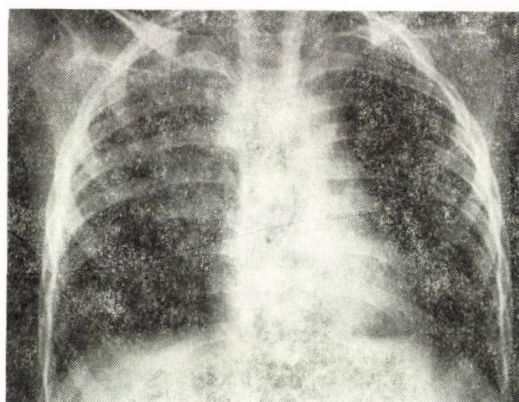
Chest X-rays of S.G. (8-year-old boy). Fascicular densities in the right upper lung
